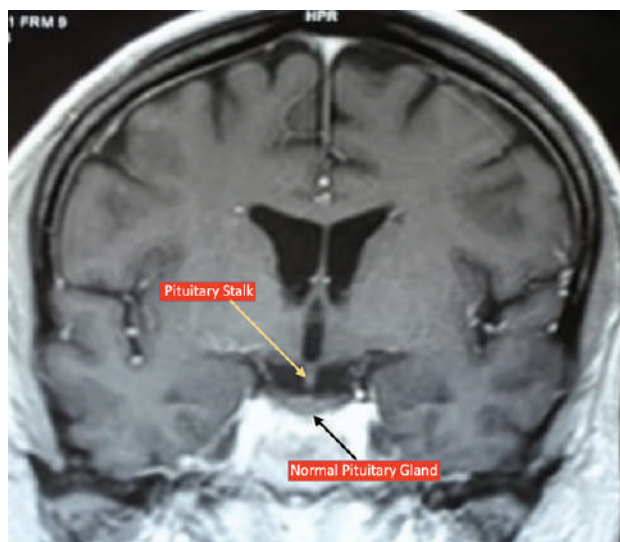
Postoperative MRI after 2nd surgery revealed normal pituitary gland. There is no residual or recurrent tumor.
